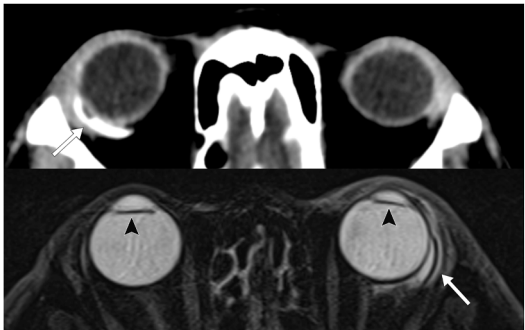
Axial CT (*top*) and T2-weighted MR sequence (*bottom*) demonstrating glaucoma drainage devices on CT and MR respectively (*white arrows*), with small associated fluid filled blebs. Bilateral intraocular lens replacements also noted (*black arrowheads*).
